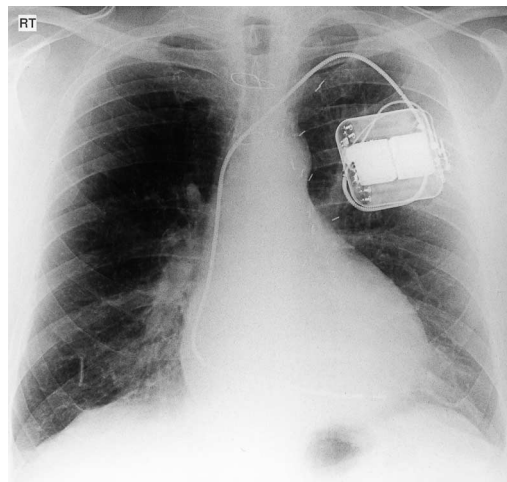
Chest X-ray showing sub-pectorally placed single chamber implantable defibrillator and lead to right ventricular apex. Note arterial clips and sternal wires of previous coronary bypass surgery.
